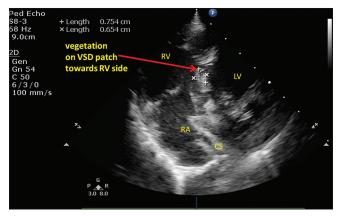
Modified apical four chamber view on transthoracic echocardiography examination showing a vegetation of size 6 × 7 mm vegetation (red arrow) was seen on the PTFE patch on the right ventricular side in. PTFE: Polytetrafluoroethylene, CS: coronary sinus; LV: Left ventricle; RA: Right atrium; RV: Right ventricle
